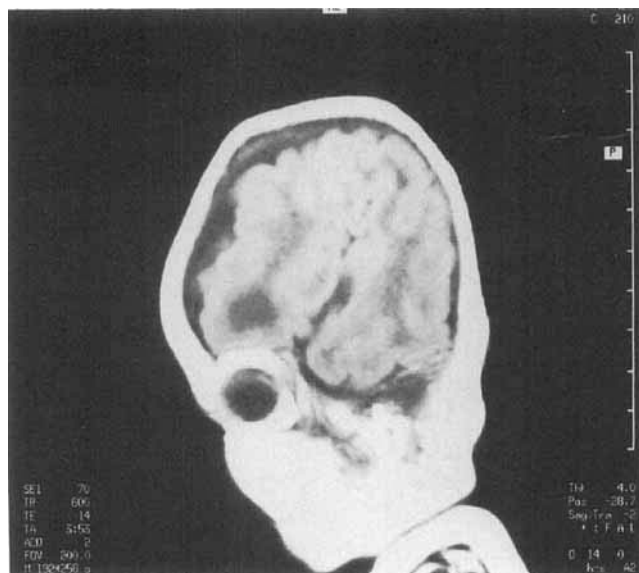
MRI sagittal T<sub>1</sub>-weighted image shows diffuse polymicrogyria and abnormal extension of the sylvian fissure to the convexity.
